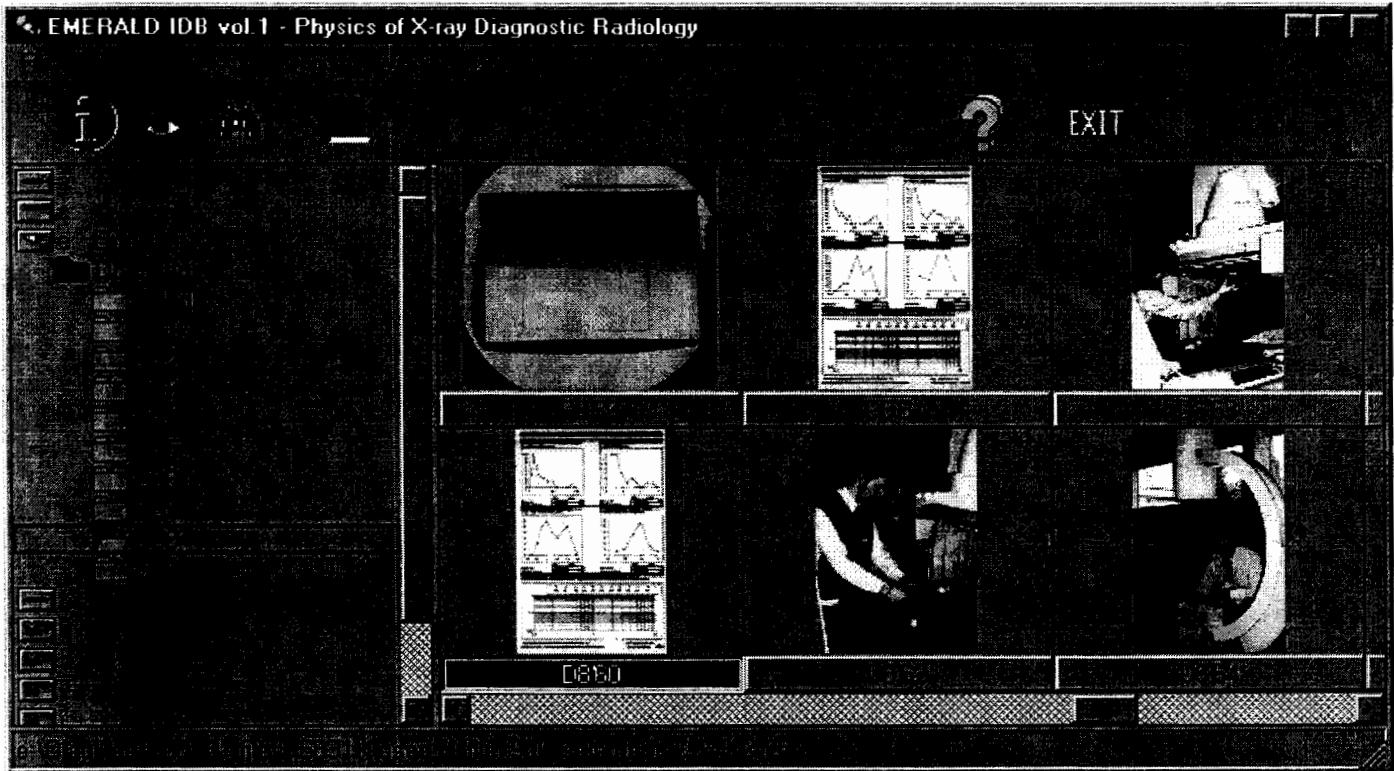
Graphical interface of the EMERALD Image Database with Thumb+Plus browser. An example from Image Directory 8, corresponding to Chapter 8 (Fluoroscopic Equipment - the task on image quality assessment) of the training module on Physics of X-ray Diagnostic Radiology.
